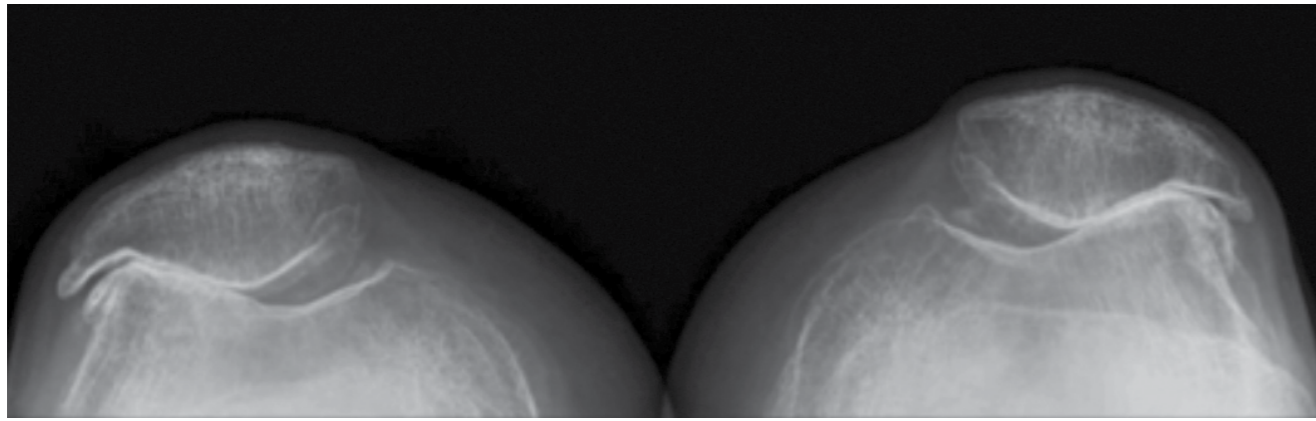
X-Ray showing severe patellofemoral osteoarthritis.
